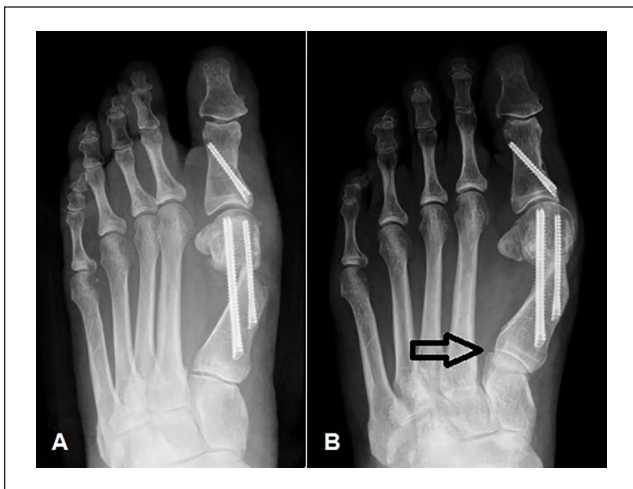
An example of first tarsometatarsal (TMT) joint subluxation following minimally invasive bunionectomy is shown. (A) Two-week postoperative radiographs show a congruent first TMT joint. (B) One-year postoperative radiographs show subluxation at the first TMT joint (arrow) with recurrence of hallux valgus.
